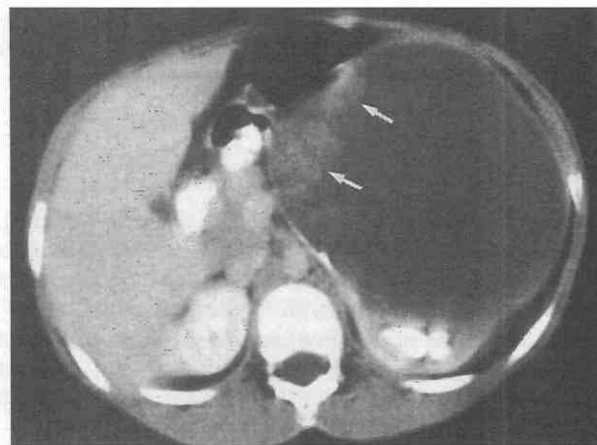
Wilms' tumor of left kidney with extensive necrosis. A contrast-enhanced CT scan shows that the tumor has a mainly fluid density. Solid and enhancing tumor elements are present medially (arrows).
